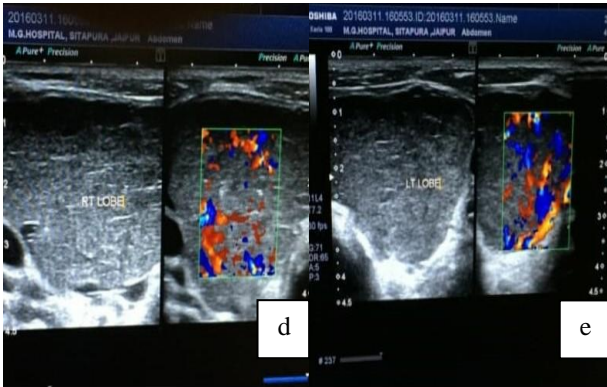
(d): Grey scale image of right and left lobe shows increase in size; (e) colour Doppler image showing increase in vascularity.
